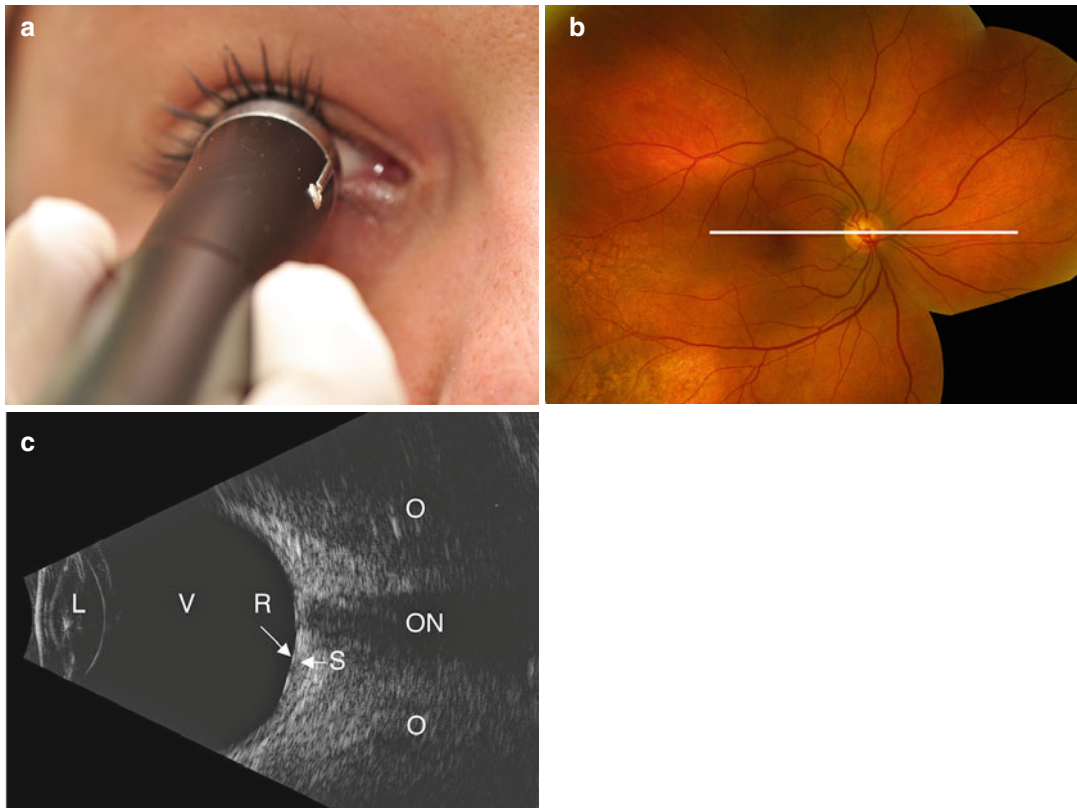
Axial probe position. B-scan probe tip placed directly over the cornea (a). Corresponding ultrasonographed fundus (b, line). Resulting B-scan image showing
